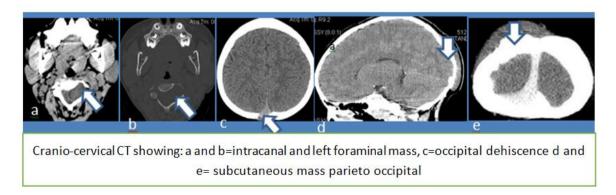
Cervical CT scan, showing the left side of the vertebral canal and an occipital mass under the galactic vertebrae with dehiscence of the lambda suture in relation to the sagittal sinus
